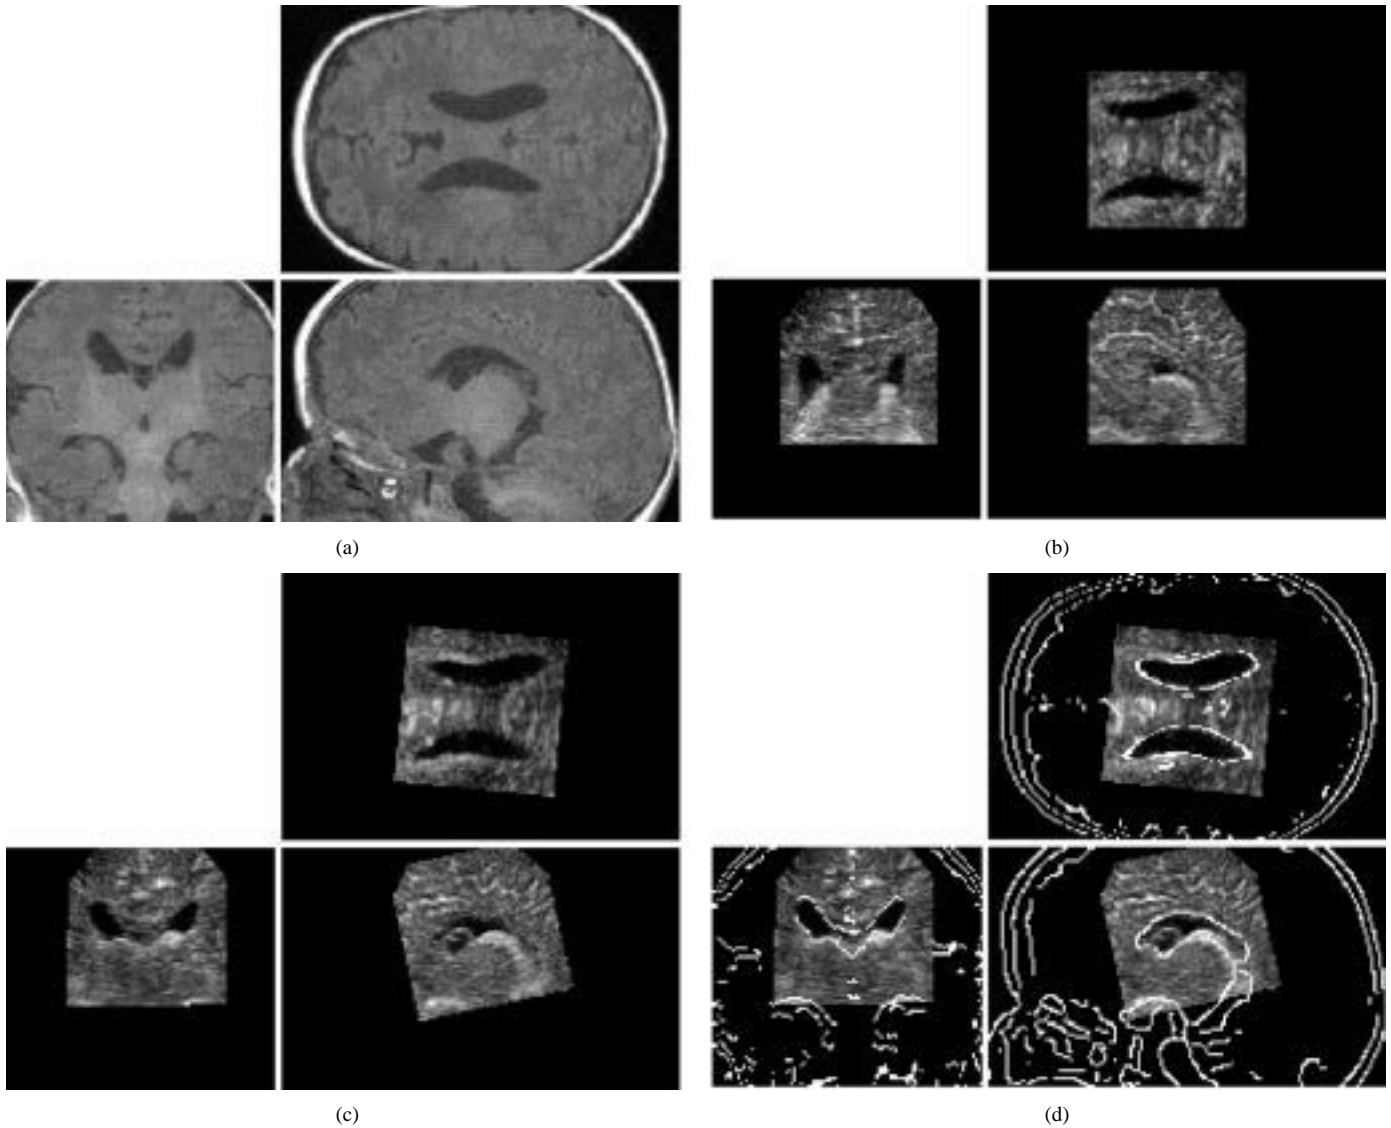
Example registration of the baby US/MR images. Note that the US volume is truncated with respect to the original acquisition. (a) MR volume (zoom) (b) US volume (manually initialized) (c) Registered US volume (d) Registered US volume with MR contours overlaid.
